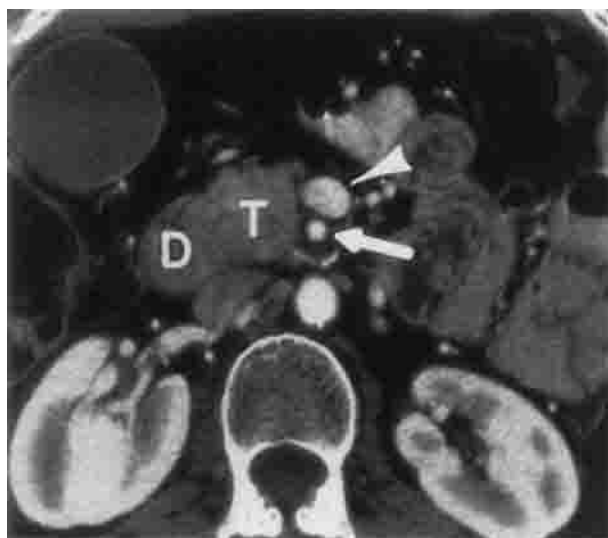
Contrast-enhanced CT scan demonstrating a resectable adenocarcinoma of the pancreatic head. Note the normal fat plane between the tumor (T) and both the superior mesenteric artery (arrow) and the superior mesenteric vein (arrowhead). D, duodenum.
